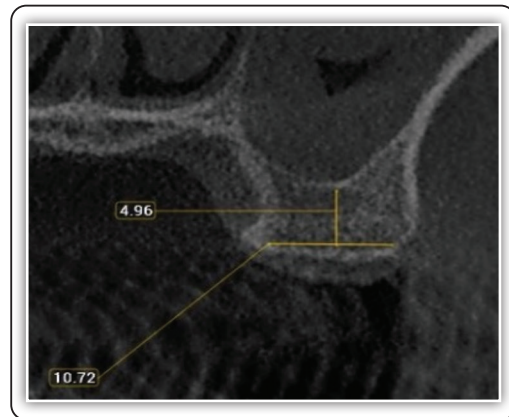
Preoperative CBCT cross section
